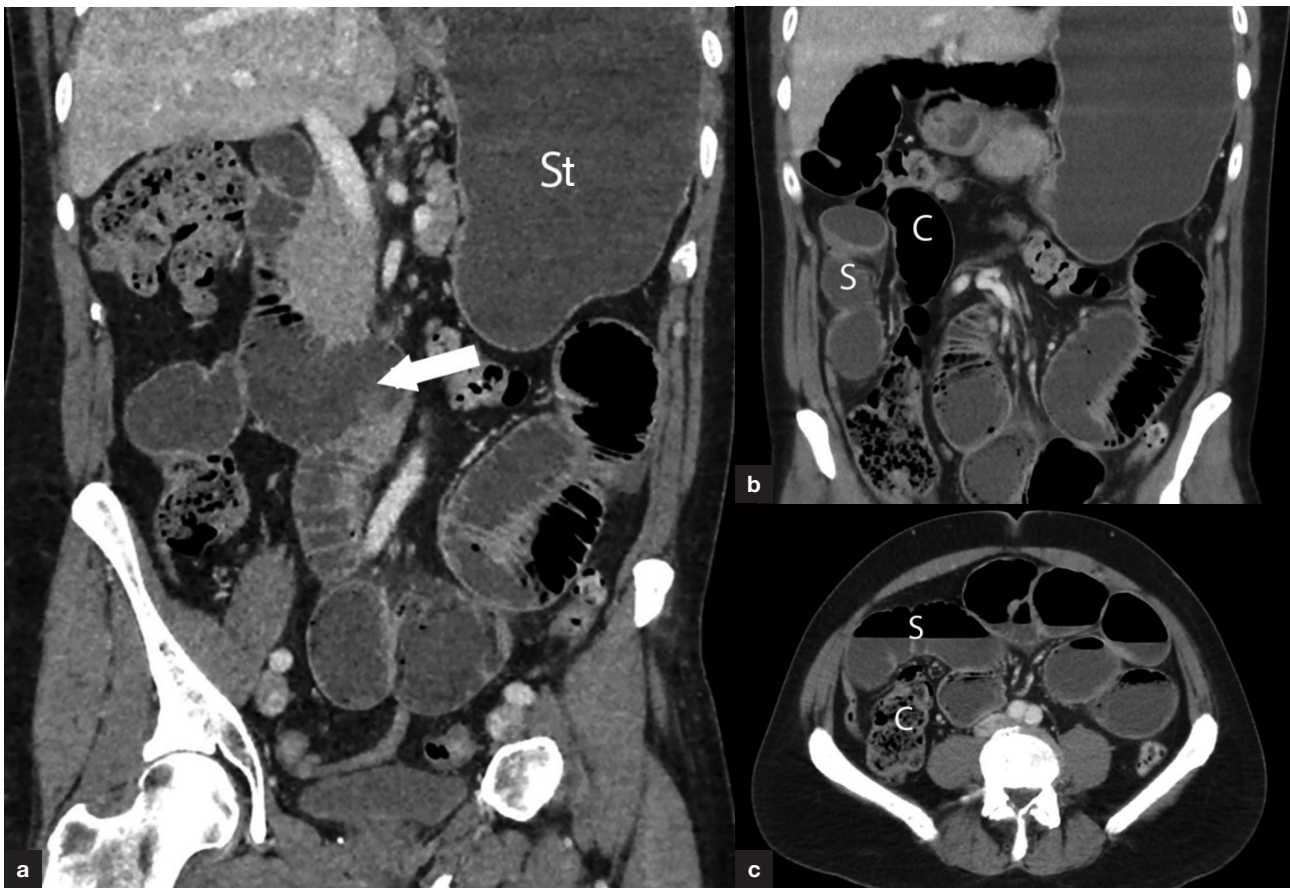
Computed tomography images. a. The third part of the duodenum is twisted and lies on the right side (arrow). Note distended stomach (St). b and c. Dilated small bowel (S) lies lateral to the ascending colon (C), with twisted mesenteric vessels.
